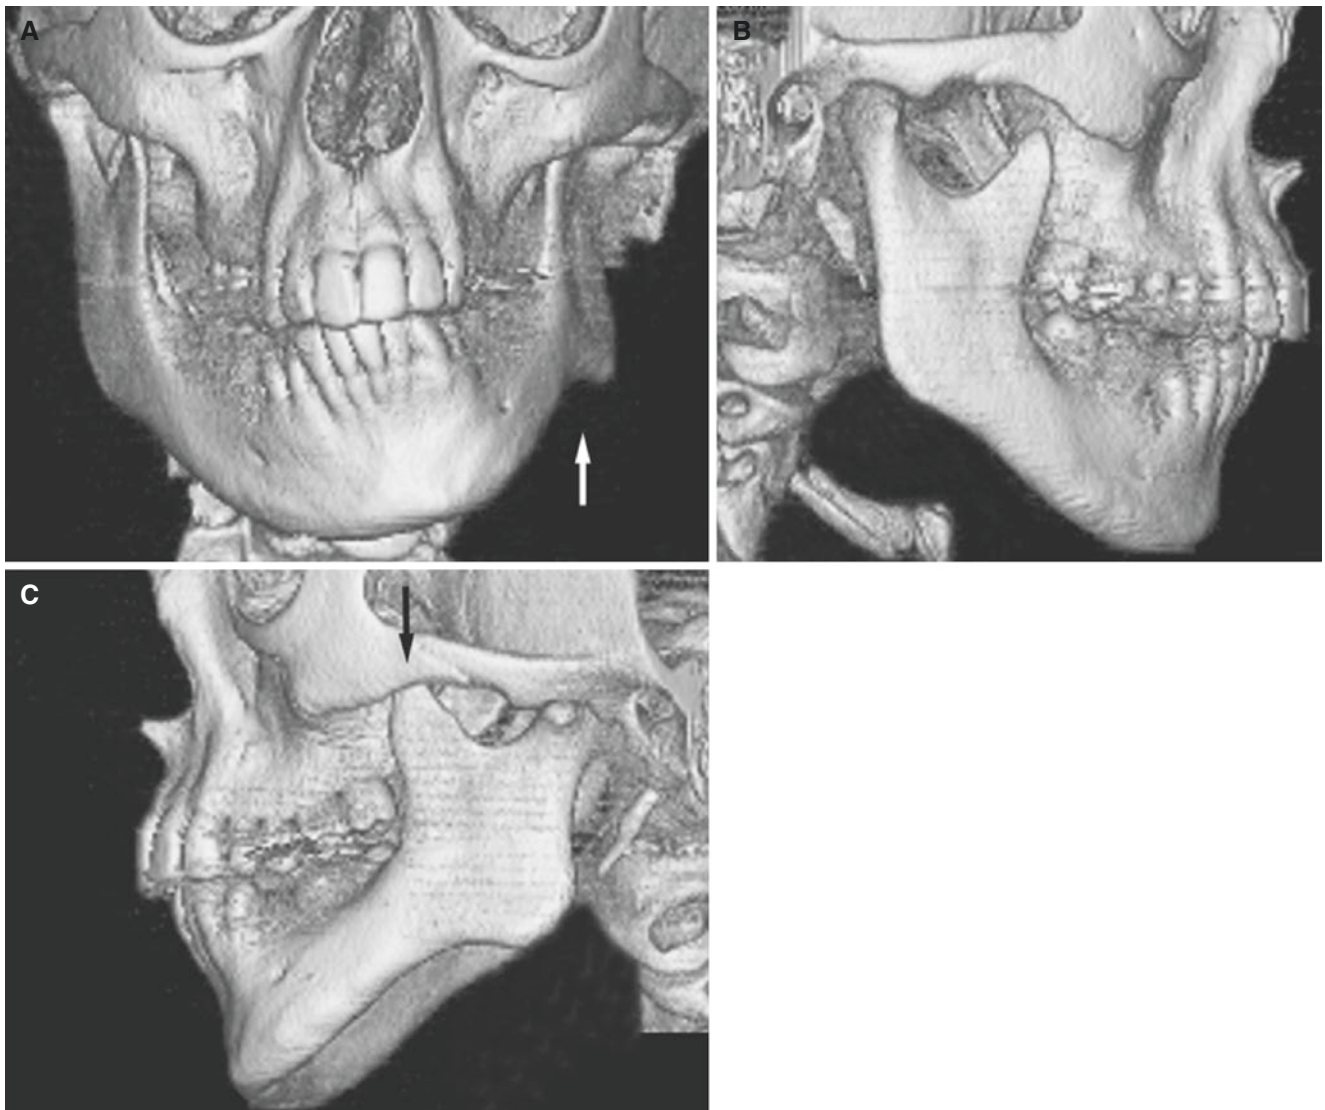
Facial asymmetry; 15-year-old male with previous trauma to the mandible. (A) 3D CT image, en face view, shows evident mandibular asymmetry with antegonial notching (*arrow*) of abnormal side. (B) 3D CT image, lateral view, shows normally developed right mandible. (C) 3D CT image, lateral view, shows underdeveloped left mandible. Note the large coronoid process (*arrow*) compared to contralateral normal side. (D) Oblique coronal CT image, mid-condyle section (*left*);
